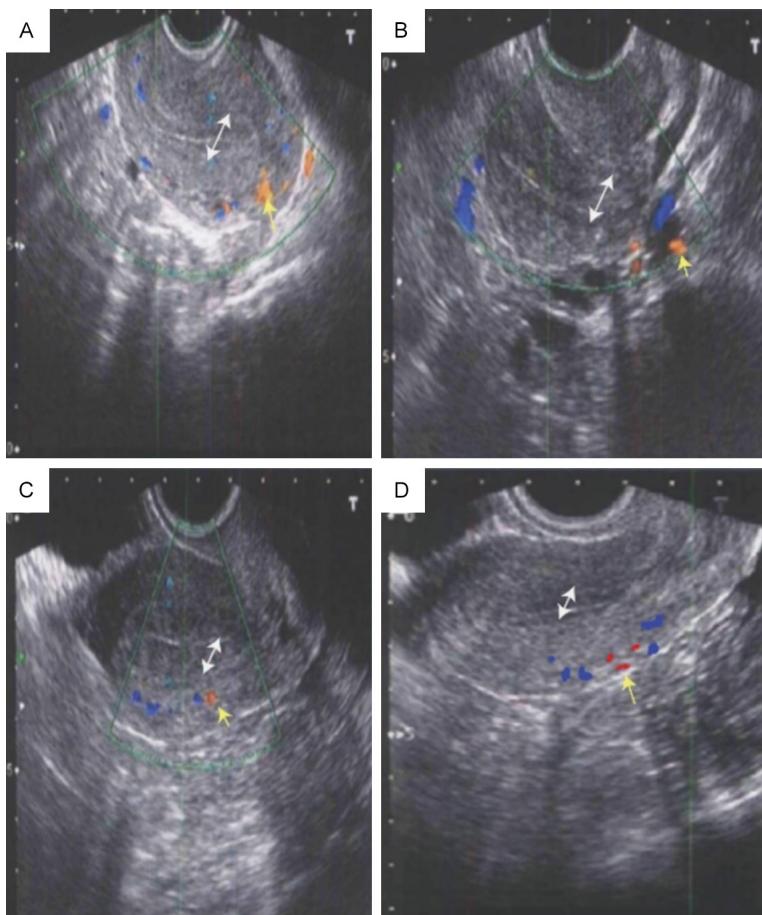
Color Doppler ultrasonographic images. A: Before surgery (control group). B: Before surgery (observation group). C: Three months after surgery (control group). D: Three months after surgery (observation group). Double-headed arrow: Endometrial thickness; Yellow arrow: Blood flow of uterine arterial.
